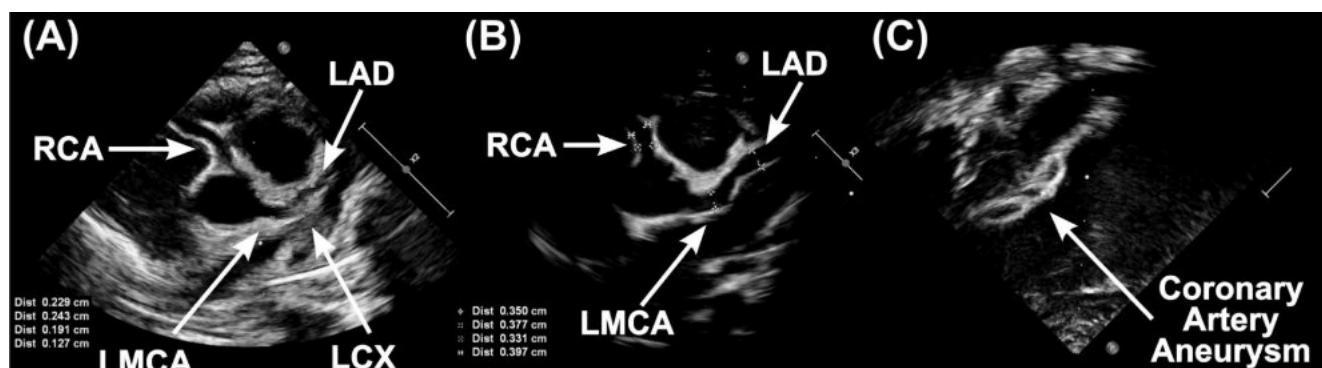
Echocardiogram: (A and B) showed dilated coronary arteries; (C) showed right coronary artery aneurysms over lateral aspect of coronary sulcus (Right). RCA – Right coronary artery; LMCA – Left main coronary artery; LAD – Left anterior descending artery; LCX – Left circumflex artery
